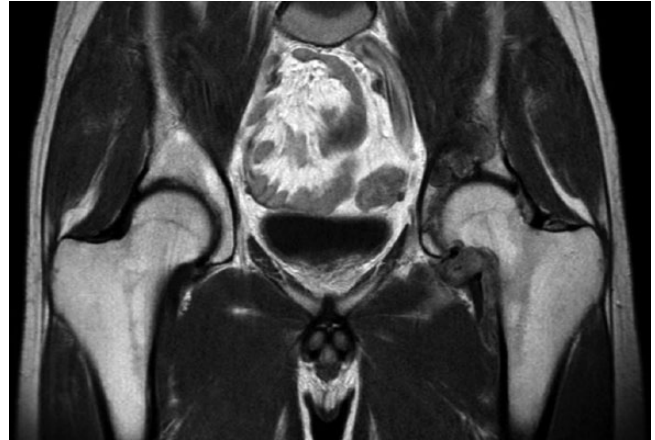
MRI of the hip: the synovium is diffuse at the hip with bone invasion. Synovium appears as hyposignal on T1-weighted sequence and enhances after the gadolinium injection.
